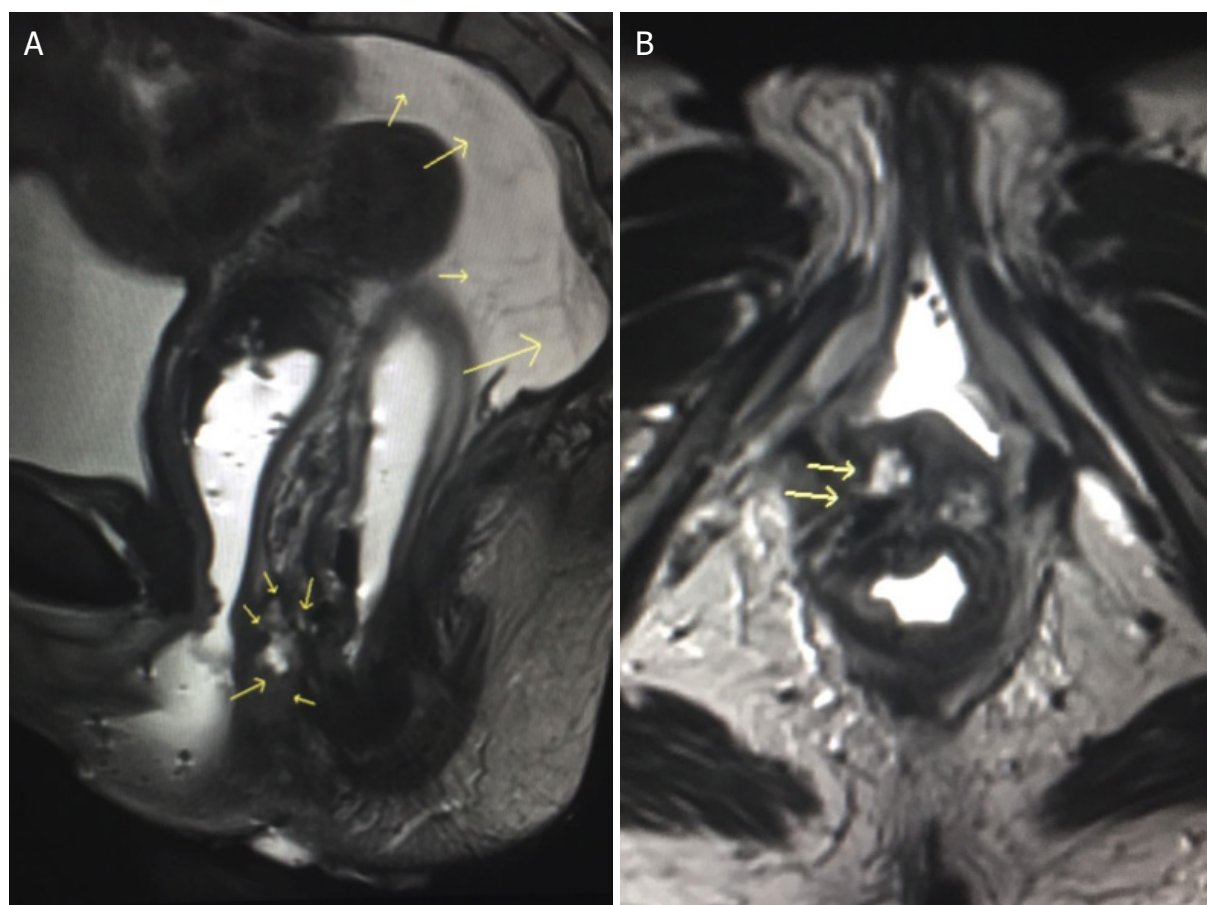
Pelvic magnetic resonance imaging (MRI) scan in a 47-year old woman with pain and febrile diarrhea 2 weeks after total mesorectal excision (TME) with colo-anal anastomosis: (A) small arrows in a circle at the bottom of the image show fluid next to the colo-anal anastomosis evoking leak. Large arrow on the right of the image shows massive intra-peritoneal fluid. Note the concern for colonic wall thickening (horizontal arrow); (B) small arrows show what was considered as extravasation of contrast in the vicinity of the colo-anal anastomosis.
